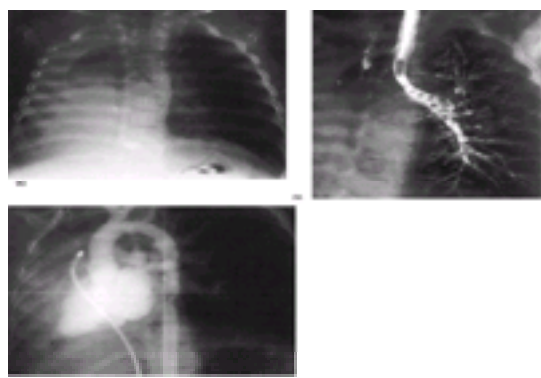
(a) Chest radiograph obtained because of mild respiratory distress in the immediate newborn period. On physical examination the heart was found in the right chest and no breath sounds were audible on that side. The chest radiograph revealed a shift of the mediastinum into the right chest which was felt to be consistent with pulmonary agenesis. (b) At 3 months of age a bronchogram was performed which revealed complete absence of the right bronchus. (c) An arteriogram was subsequently obtained after the child had suffered multiple pulmonary infections. It demonstrated the heart occupying the right hemithorax and a single pulmonary artery to the left lung.
